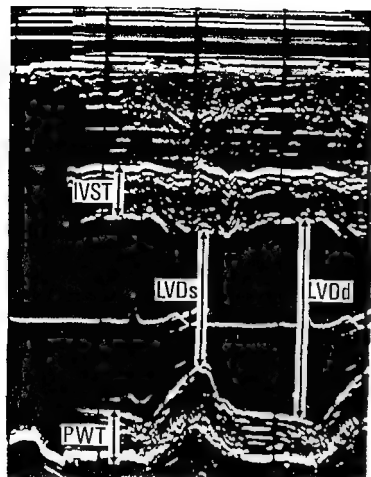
Echocardiographic recording of left ventricular diameter and wall thickness. The damping control is abruptly reduced during the recording to delineate the pericardial and endocardial echoes. LVDd = left ventricular diameter at end diastole. LVDs = left ventricular diameter at end systole. IVST = thickness of the interventricular septum. PWT = thickness of the posterior left ventricular wall.
